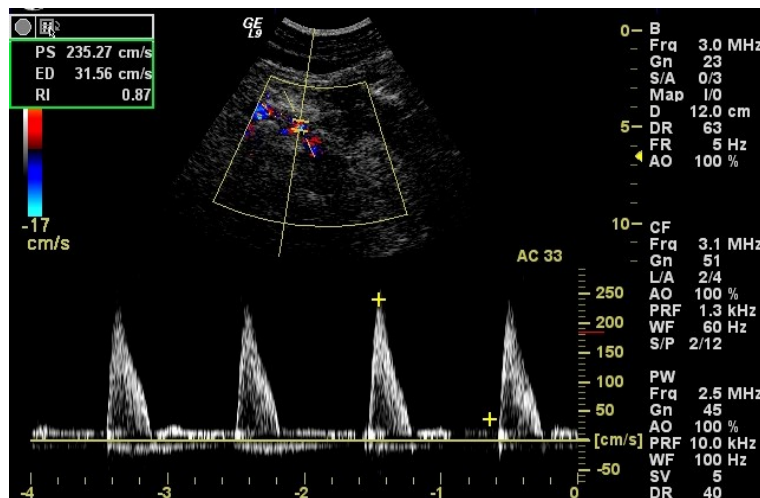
High-resistance Doppler spectrum in superior mesenteric artery after eight-hours fasting period. Early diastolic retrograde flow can be seen.
